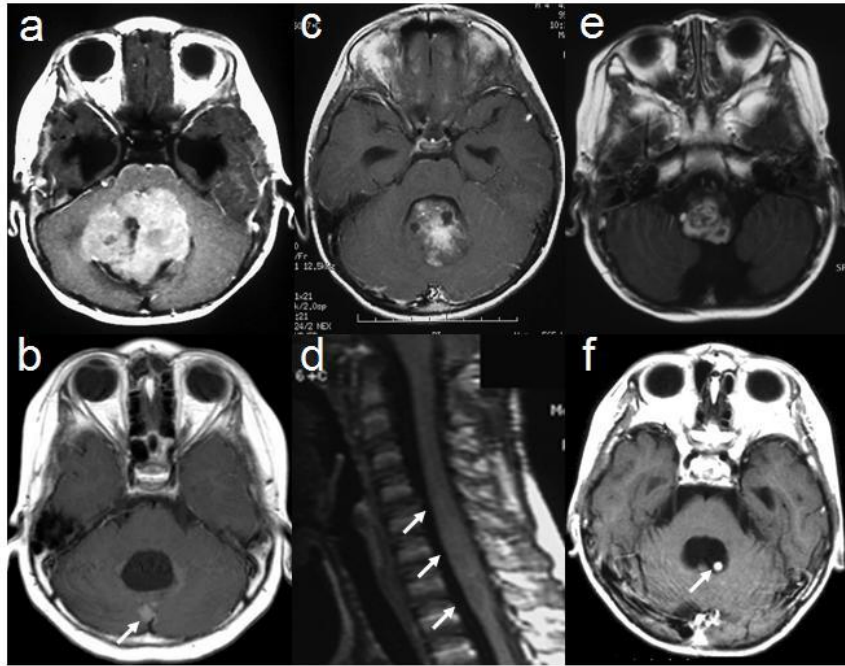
(Case 1) a, Preoperative T1-weighted magnetic resonance (MR) imaging with gadolinium-diethylenetriaminepenta-acetic acid (Gd-DTPA) demonstrating a mass lesion in the cerebellar vermis. b, Follow-up MR imaging, obtained in February 1999, revealing an enhanced recurrent tumor in the cerebellar vermis (arrow). (Case 2) c, Preoperative T1-weighted MR imaging with Gd-DTPA showing a mass lesion in the cerebellar vermis. d, T1-weighted MR imaging with Gd-DTPA of the spine demonstrating spinal cord swelling from C5 to Th1 in July 2003 (arrow). (Case 3) e, Preoperative T1-weighted MR imaging with Gd-DTPA revealing a heterogeneously enhanced mass lesion in the fourth ventricle and the cisterna magna. f, Follow-up MR imaging, obtained in April 2006, showing an enhanced recurrent tumor in the fourth ventricle (arrow).
